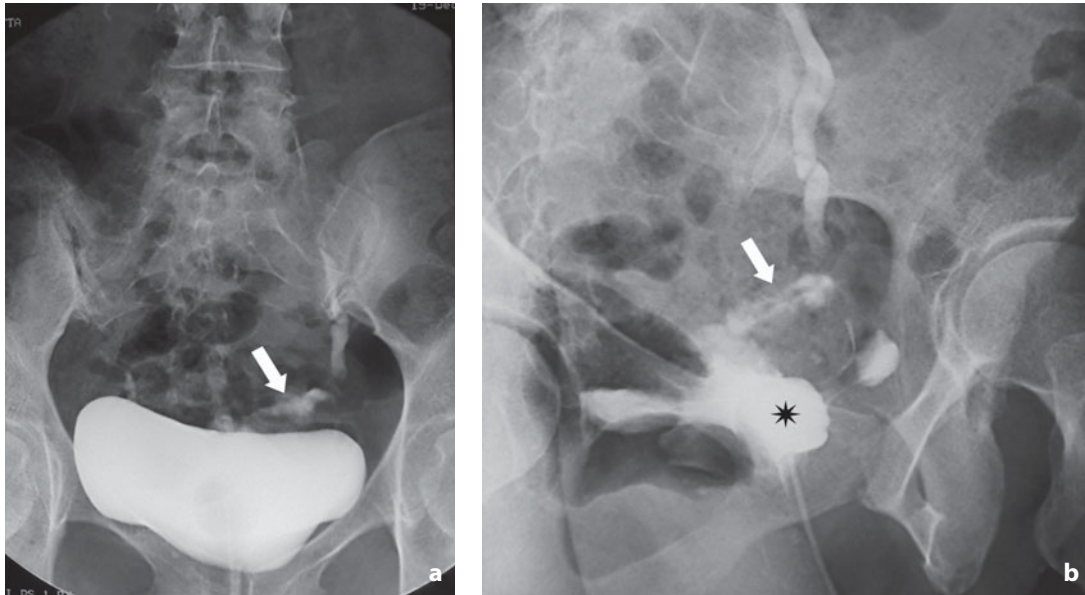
Urography. Ureterovaginal fistula. Appearance after radical hysterectomy due to cervical cancer. a Urographic image shows the leakage of iodinated urine (*arrow*) with opacification of the vagina (*asterisk*) shown in the detailed radiograph (b)
